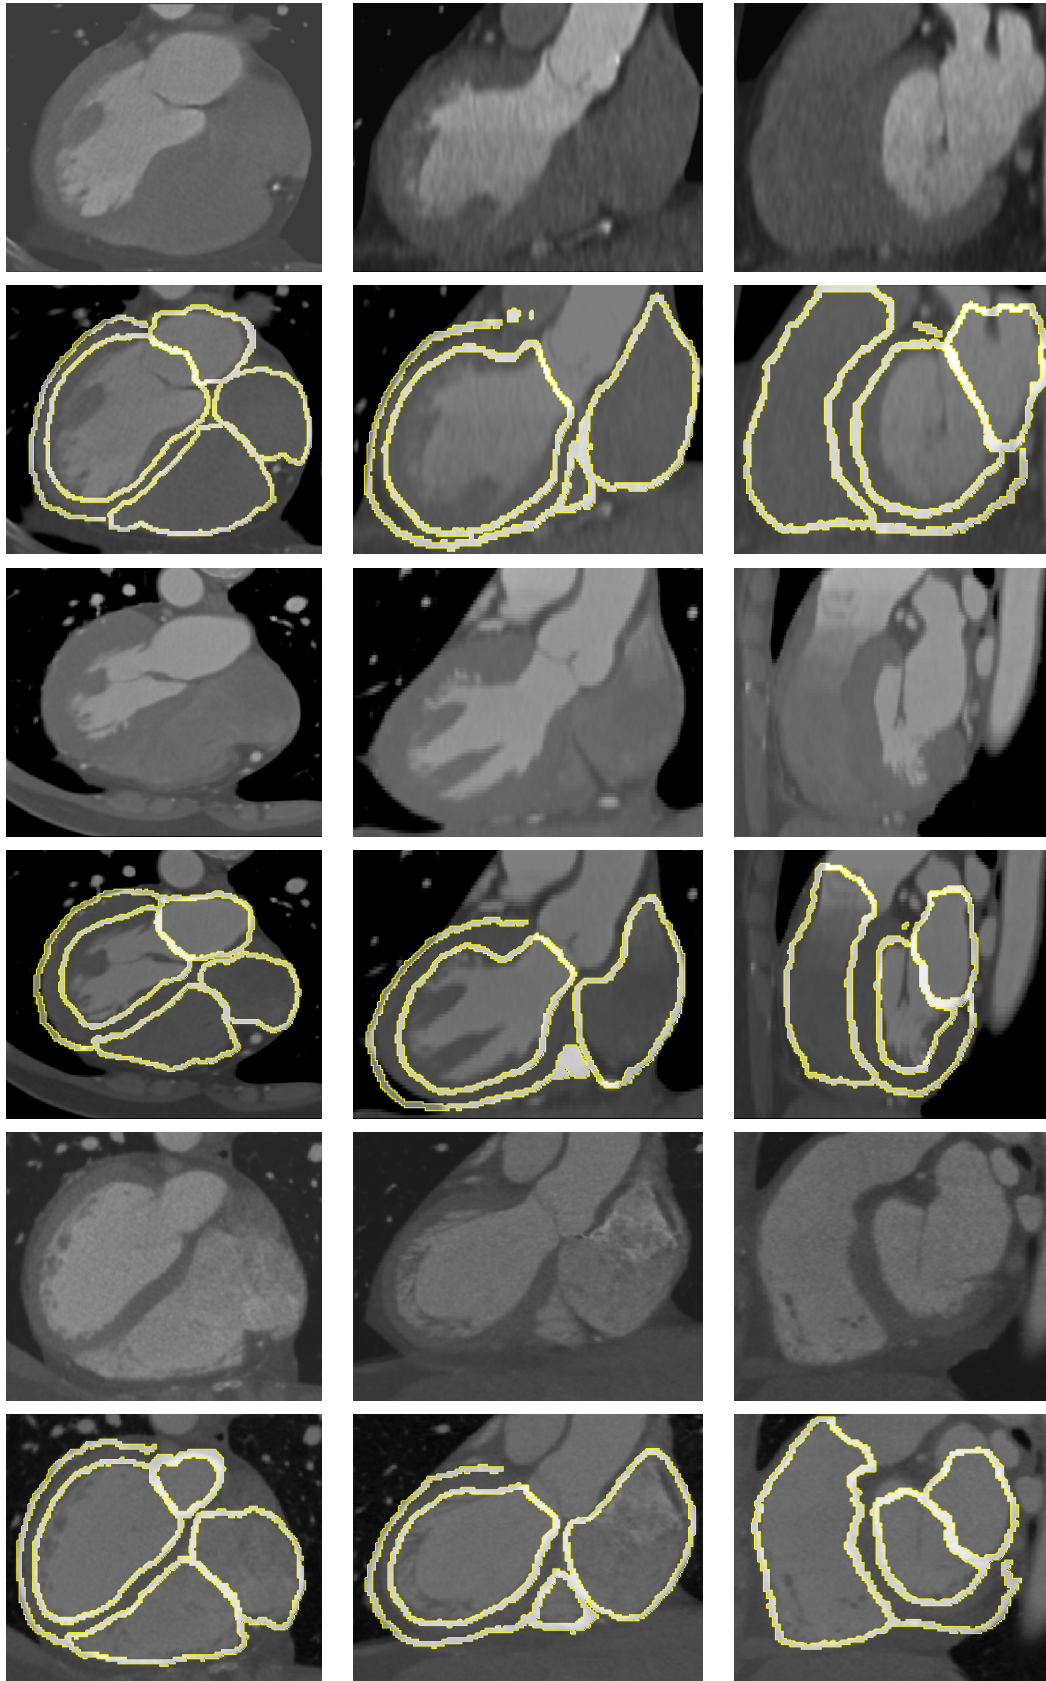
Examples of CTA image segmentation. (1st, 3rd and 5th rows): CTA example images in three views; (2nd, 4th and 6th rows): the CTA images overlaid with segmentation surfaces shown in light-grey with yellow contour.
